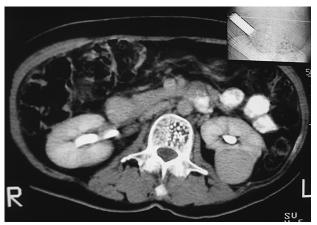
Computed tomography showed an upper pole left kidney mass.
